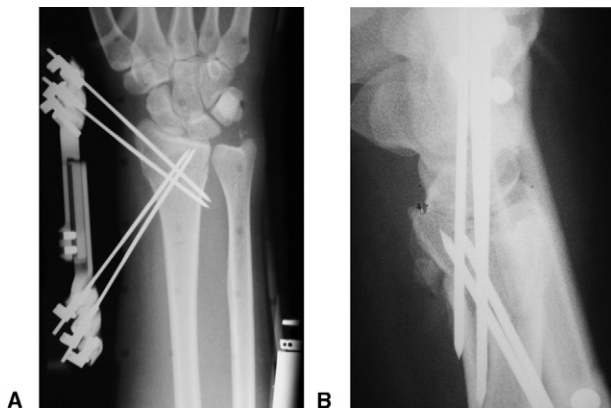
Radiograph of a DRF with the CPX device. A PA view, B lateral view.
